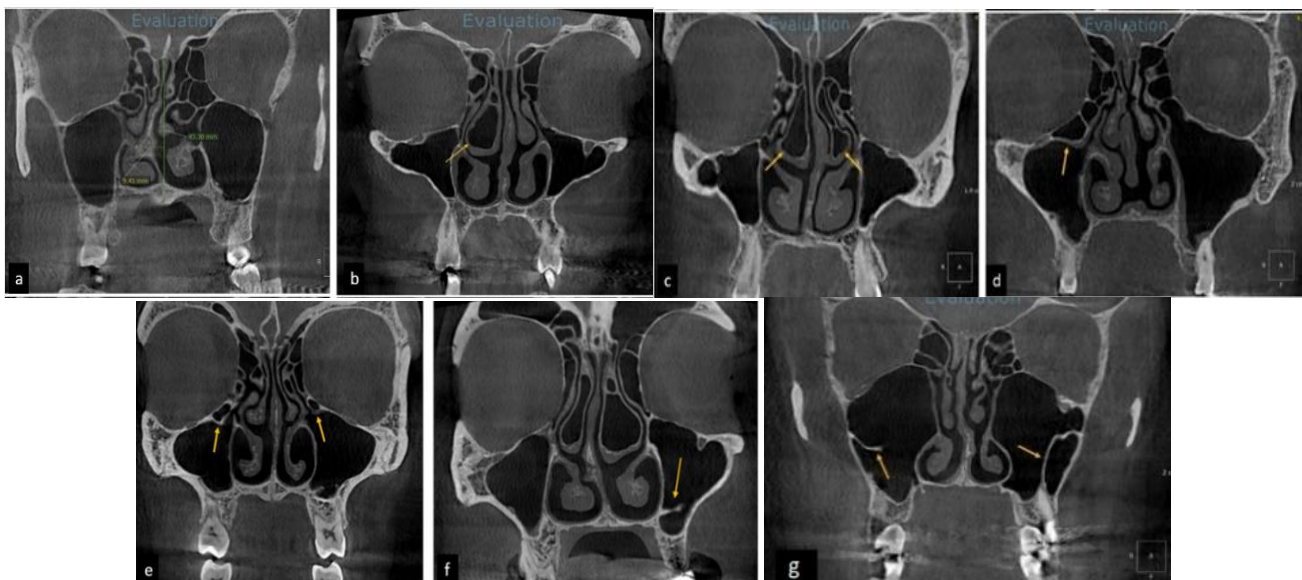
Coronal CBCT images of maxillary sinus and osteomeatal complex shows (a):Nasal septum deviation to the right, (b) Unilateral concha bullosa, (c) Bilateral concha bullosa, (d) Unilateral haller cell, (d) Bilateral haller cell,(e) Unilateral maxillary sinus septa, (f) Bilateral maxillary sinus septa
